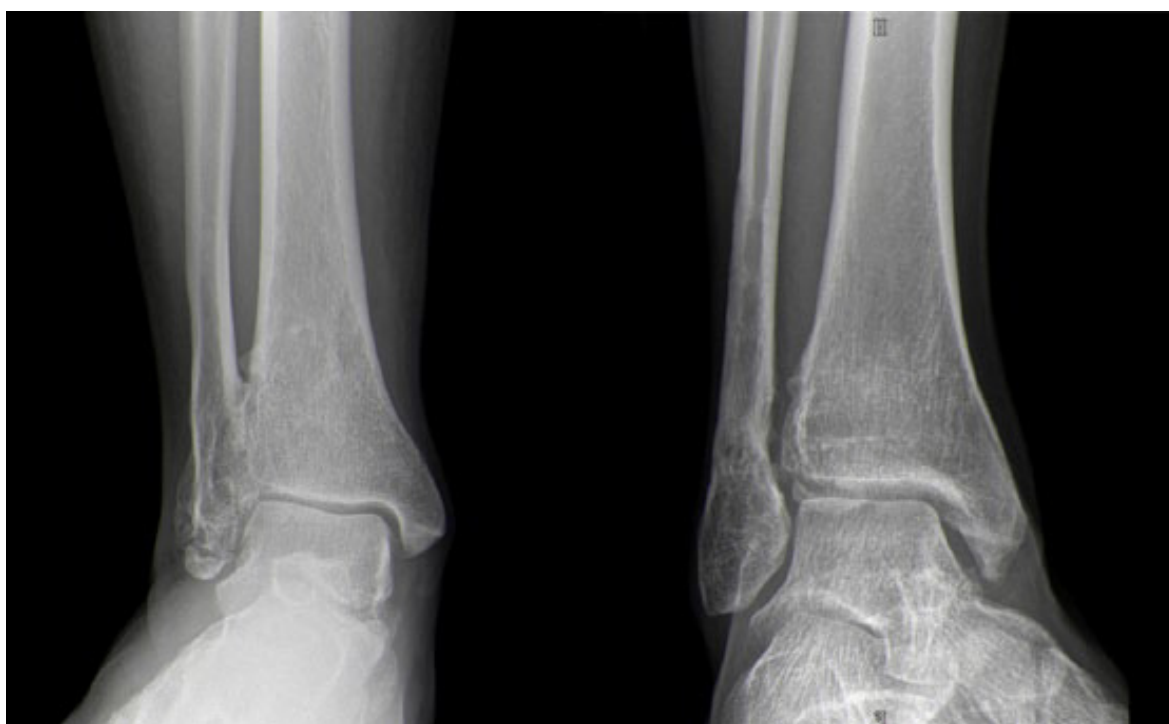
Anteroposterior radiographs of 2 patients with chronic ligamentous syndesmotic injuries. Left: Autofusion of the syndesmosis is seen. Right: Mild heterotopic ossification and early degenerative changes are seen.
